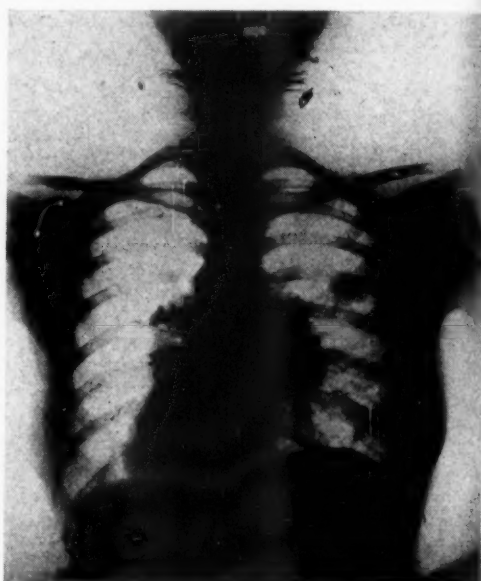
(Kruskal and Levitt). Roentgenogram of chest, showing mediastinal adenitis.
